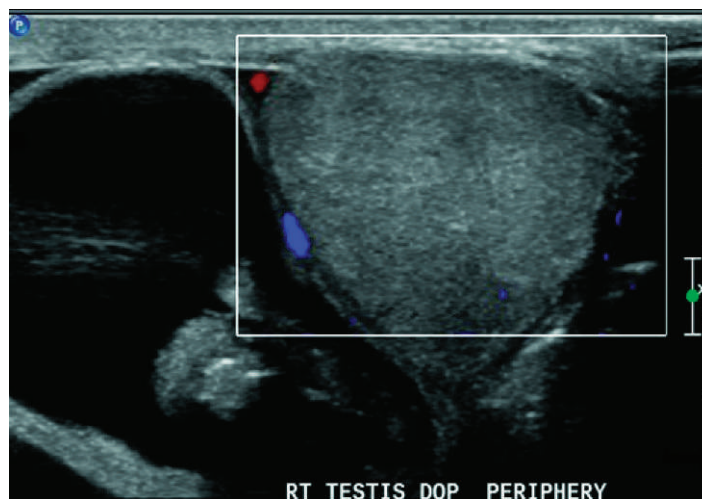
Ultrasonogram demonstrating no blood flow to the right testicle owing to the adjacent bowel within the scrotum.
